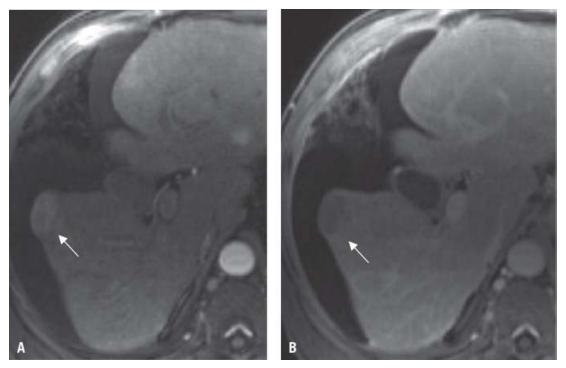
Hepatocellular carcinoma (HCC)—multiphase liver MRI shows mass hyperenhancement on arterial phase image (A, *arrow*) and washout appearance on portal venous phase image (B, *arrow*) relative to background liver. Dynamic multiphase imaging is essential for demonstrating features of HCC. These features in combination allow for noninvasive definitive diagnosis of HCC.
